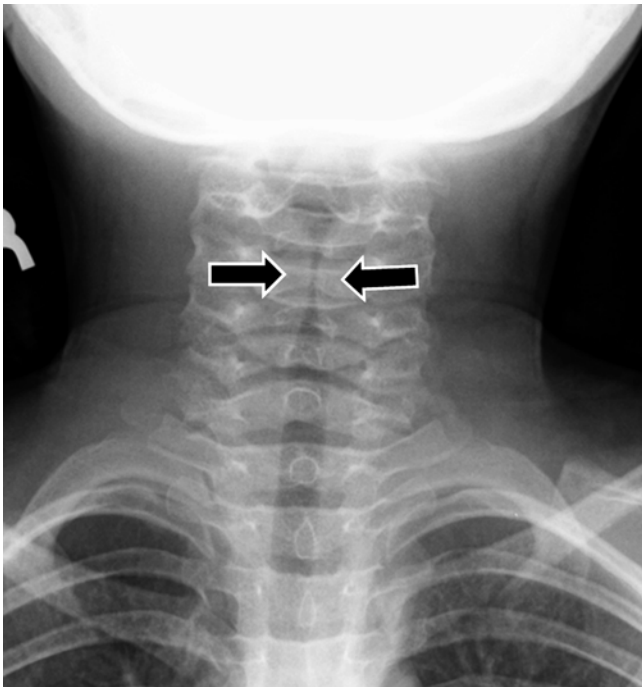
Croup in a 2-year-old boy who presented with “barking cough.” Frontal radiograph shows symmetric subglottic narrowing (*arrows*), with loss of normal shouldering
